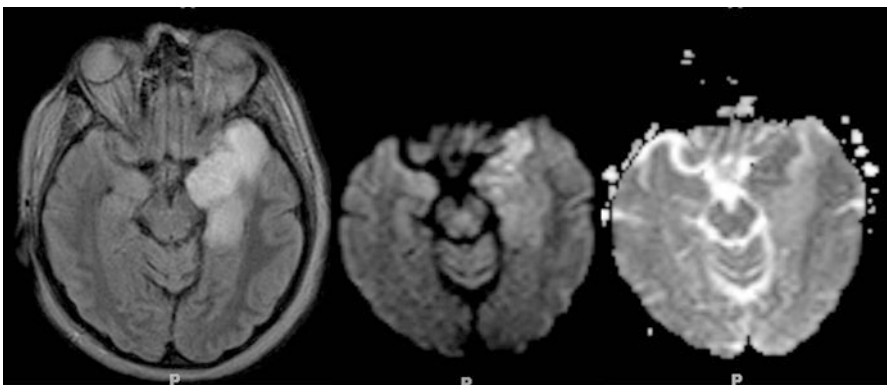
T2-FLAIR image (*left*) demonstrating edema in the left anterior and mesial temporal lobe. DWI-trace and ADC images (*middle* and *right*) demonstrate areas of restricted diffusion consistent with Herpes infection in HIV+ patient (Images are the property of Dr. Haris Sair and the Johns Hopkins School of Medicine Neuroradiology teaching file)
